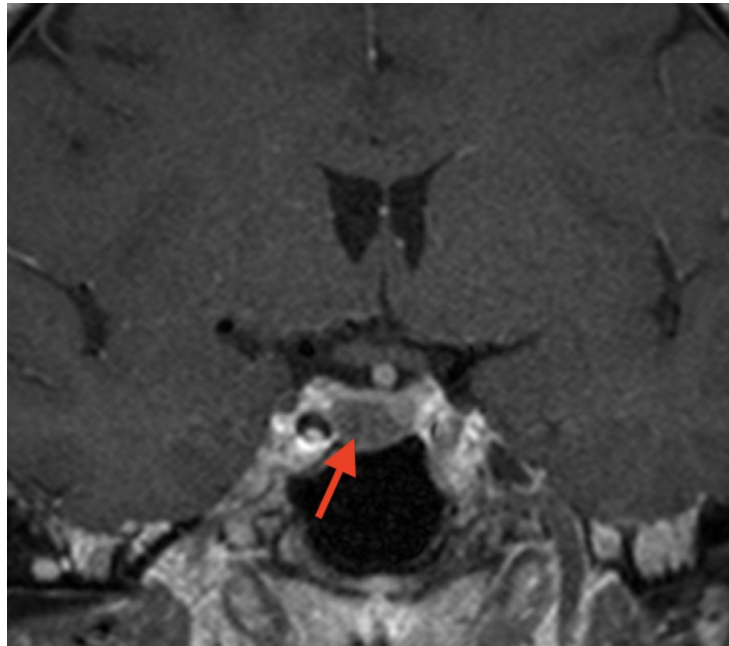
Preoperative MRI – right-sided pituitary adenoma (red arrow).
